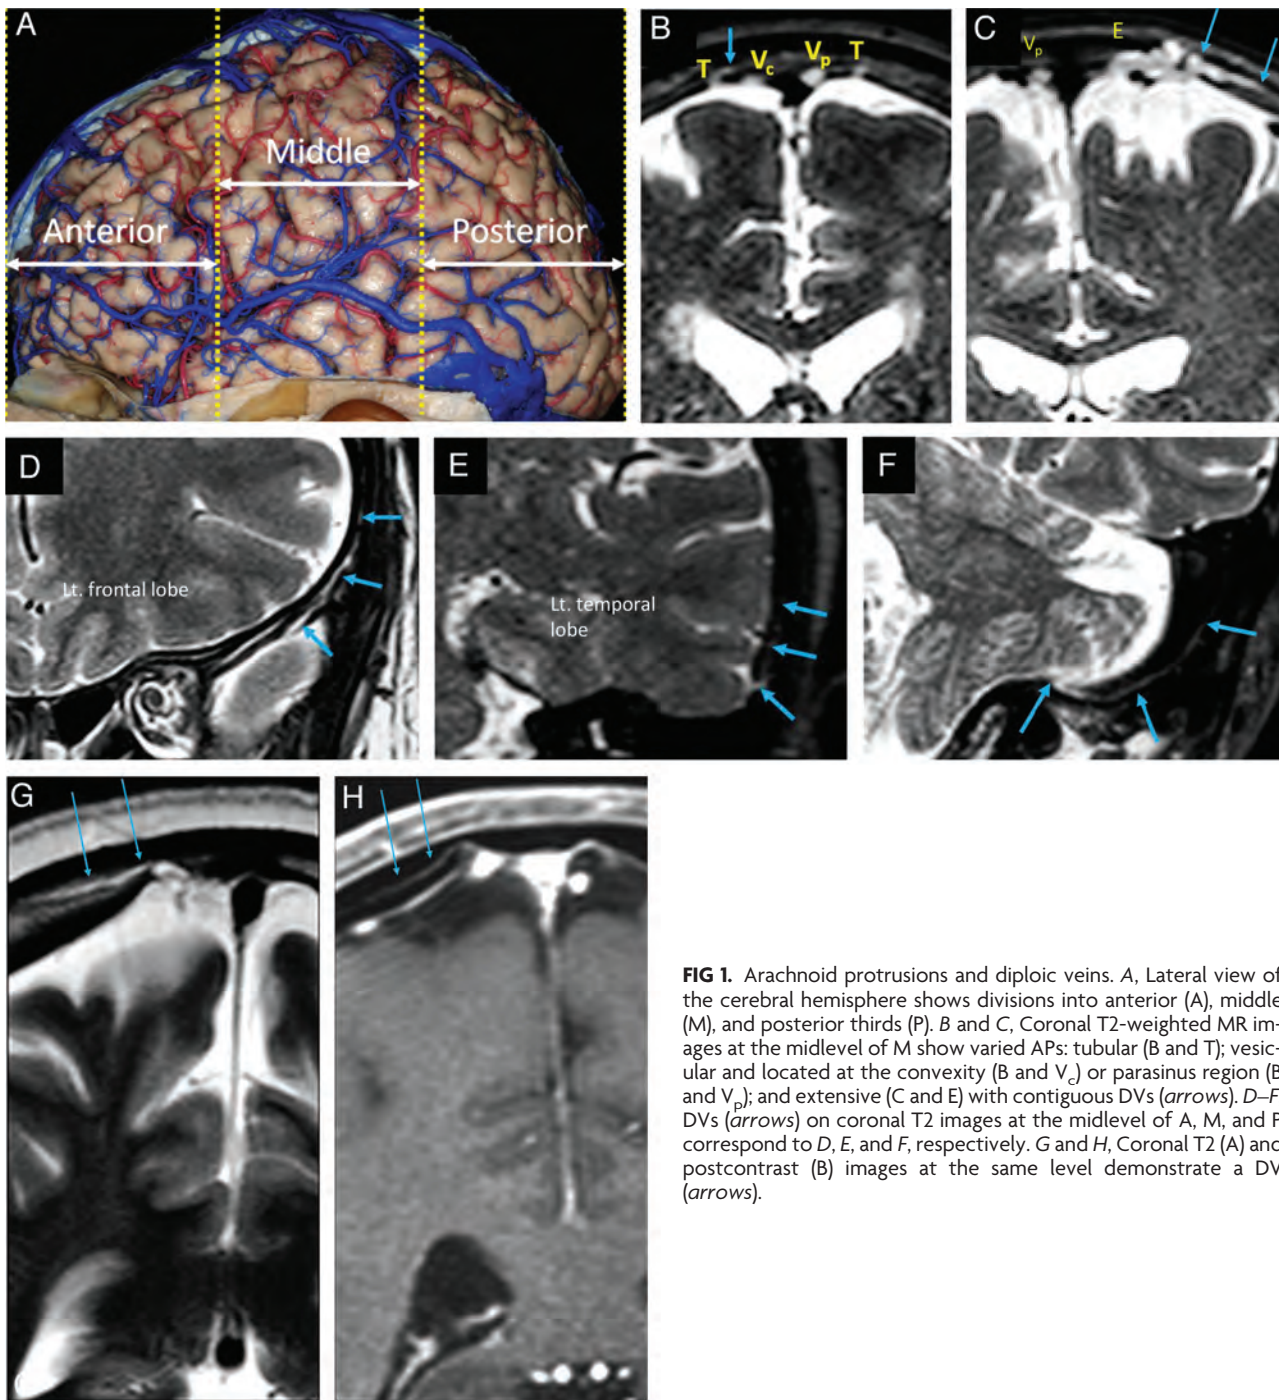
Arachnoid protrusions and diploic veins. A, Lateral view of the cerebral hemisphere shows divisions into anterior (A), middle (M), and posterior thirds (P). B and C, Coronal T2-weighted MR images at the midlevel of M show varied APs: tubular (B and T); vesicular and located at the convexity (B and V_c) or parasinus region (B and V_p); and extensive (C and E) with contiguous DVs (arrows). D–F, DVs (arrows) on coronal T2 images at the midlevel of A, M, and P correspond to D, E, and F, respectively. G and H, Coronal T2 (A) and postcontrast (B) images at the same level demonstrate a DV (arrows).
